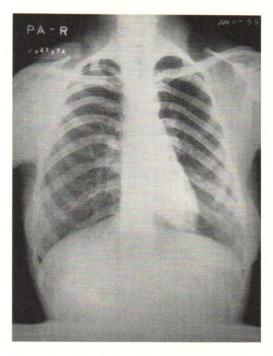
Case 3. Roentgenogram of chest showing fourth and fifth ribs bifurcated bilaterally.
